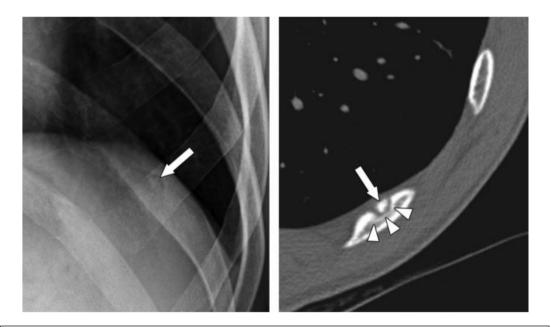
Osteoid osteoma in posterior rib. AP radiograph reveals a nidus in rib with central calcification and mild sclerosis. CT axial plain image depicts nidal calcification (arrow) in rib's anterior cortex(4).
